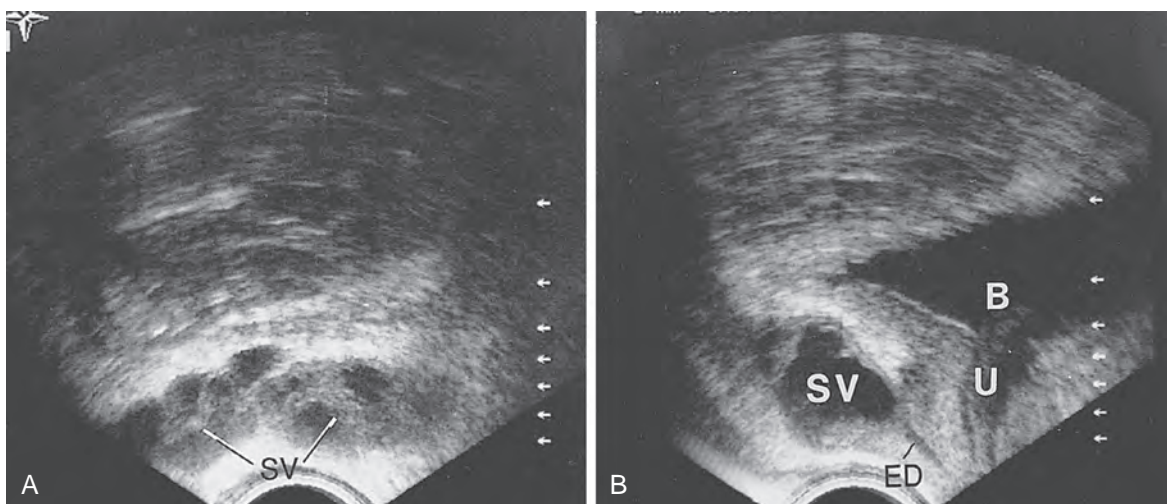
Transrectal ultrasound examination of normal seminal vesicles. A, Transverse view. B, Sagittal view. B, bladder; ED, ejaculatory duct; SV, seminal vesicle; U, urethra.
